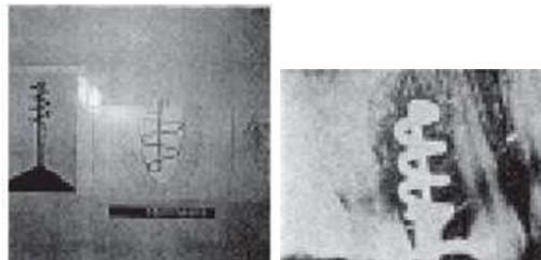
Formiggini's implant and radiograph revealing bone loss around the implant.
